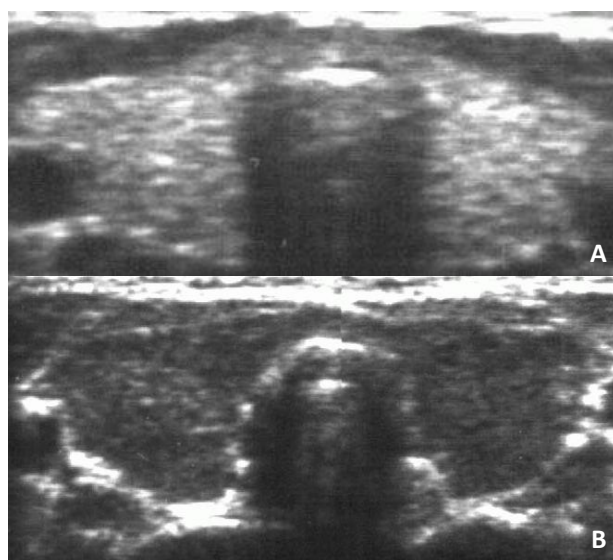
Ultrasound images of normal thyroid (A) and thyroid with increasing number of damaged follicles (B).
